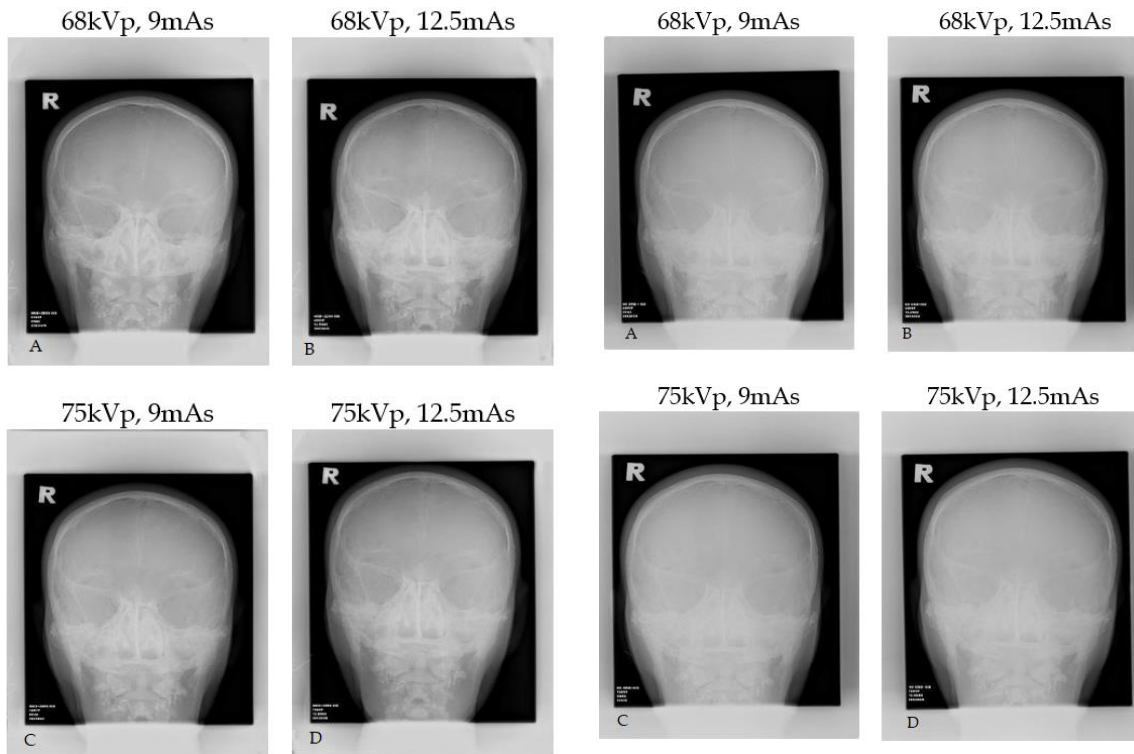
Radiographs of AP Skull with Grid Technique
